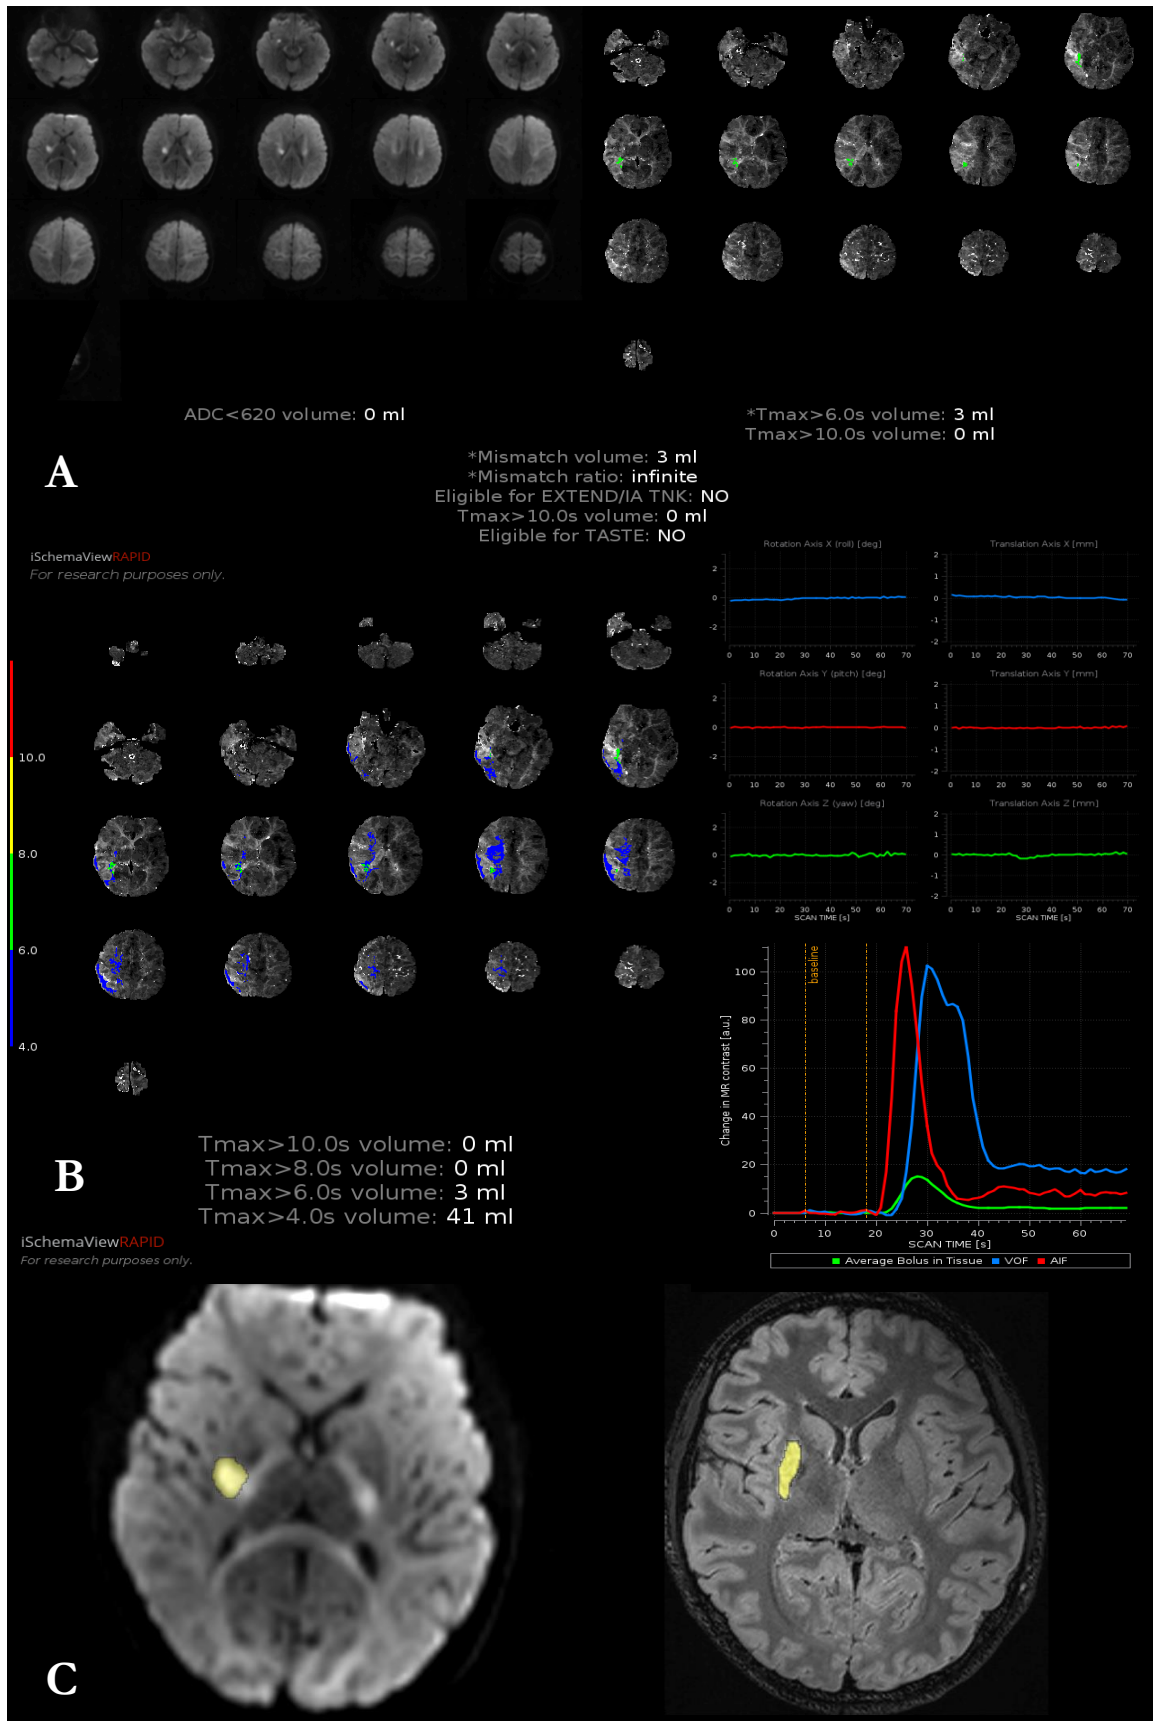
RAPID output and manual segmentation Case study 3 - A) Automated mismatch segmentation core (left) hypoperfusion (right) using standard RAPID thresholds (B) Alternate  $T_{max}$  thresholds, head motion, and AIF curves. (C) Manual segmentation of acute DWI lesion 3.6mls (left) and chronic T2 FLAIR lesion 4.8mls (right)
